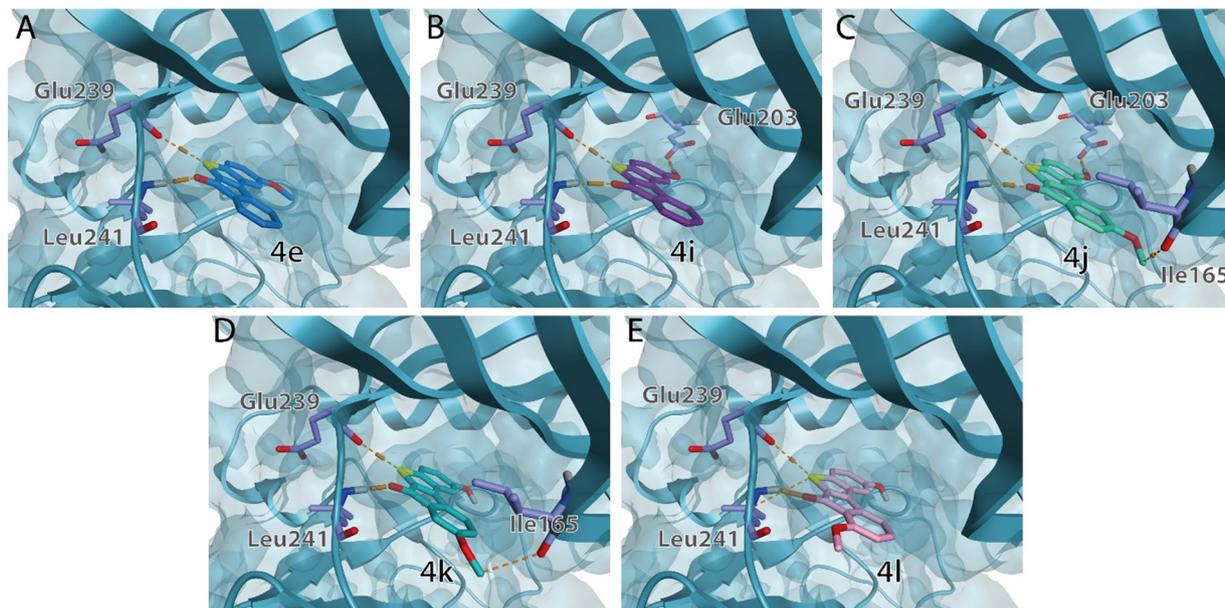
Top docking poses obtained for the 5 most potent hits 4e, 4i, 4j, 4k, 4l (A, B, C, D and E respectively), obtained from the study with the X-ray structure of DYRK1A (PDB: 5AIK). Stabilizing interactions are highlighted in orange. Compounds 4a–m representations are available in ESI† (Fig. S3).
